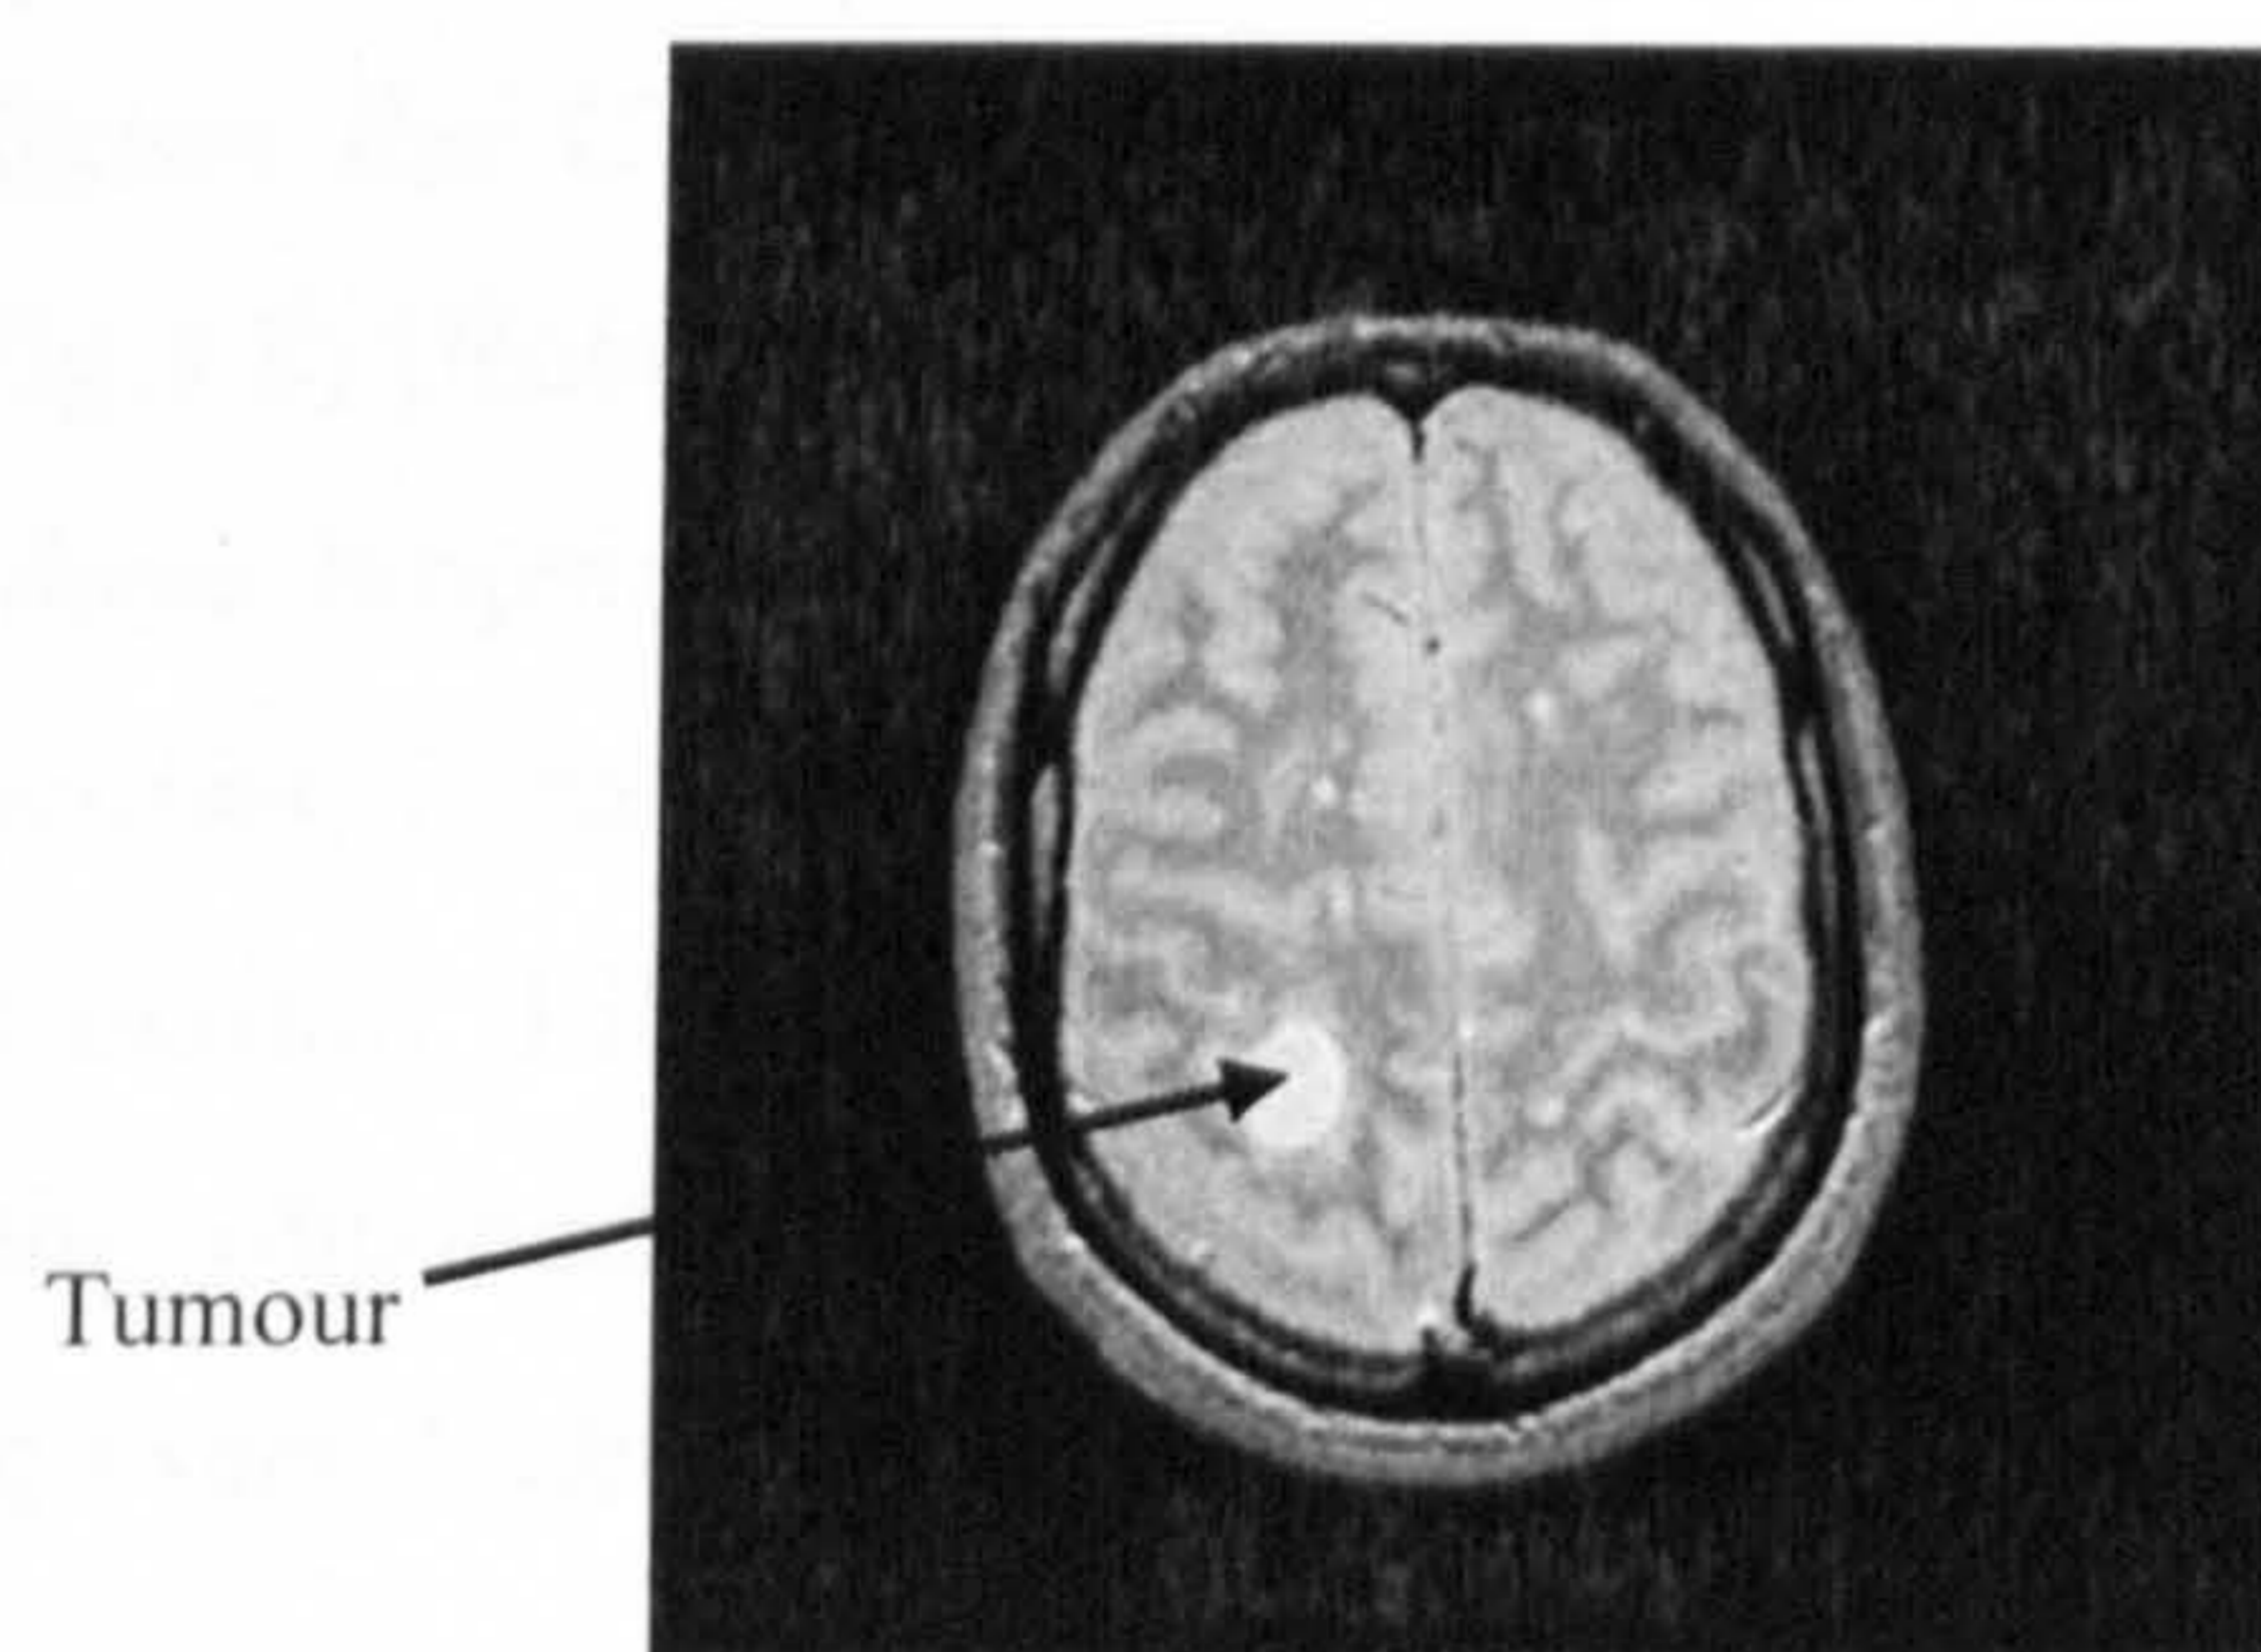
T₂-weighted MR image of brain tumour [Srdanovic 1998].
